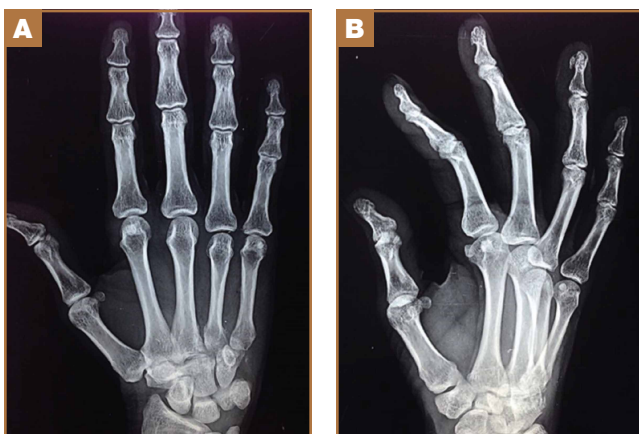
Preoperative (A) anteroposterior and (B) lateral radiographs showing radiopalmar dislocation of the fifth carpometacarpal joint.
